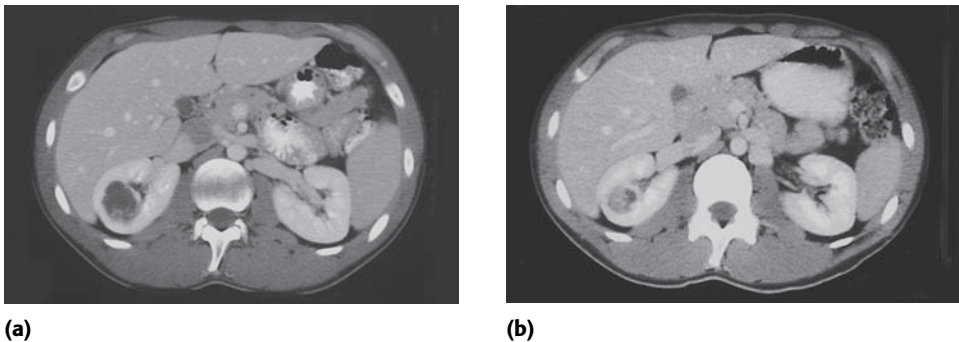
Von Hippel–Lindau syndrome. Post-contrast CT abdominal scans from the same patient taken in January 2001 (a) and January 2003 (b). Right central renal lesion demonstrates a change from predominantly cystic to predominantly solid over this time interval.
